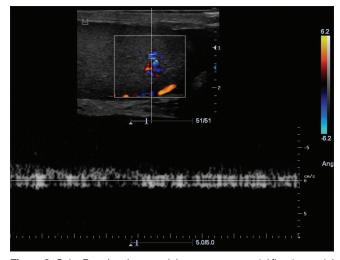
Color Doppler ultrasound demonstrates arterial flow in arterial part of the lesion
